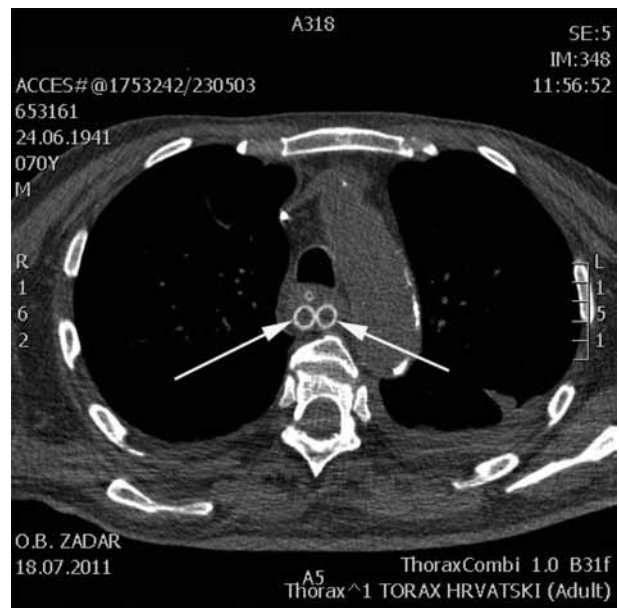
Drainage tubes were placed in the mediastinum and retropharyngeal space after cervical incision (A); computed tomography (CT) scan shows (arrows) two parallel drains in the posterior space of the mediastinum and the nasogastric tube (A, transverse view; B, frontal view).
